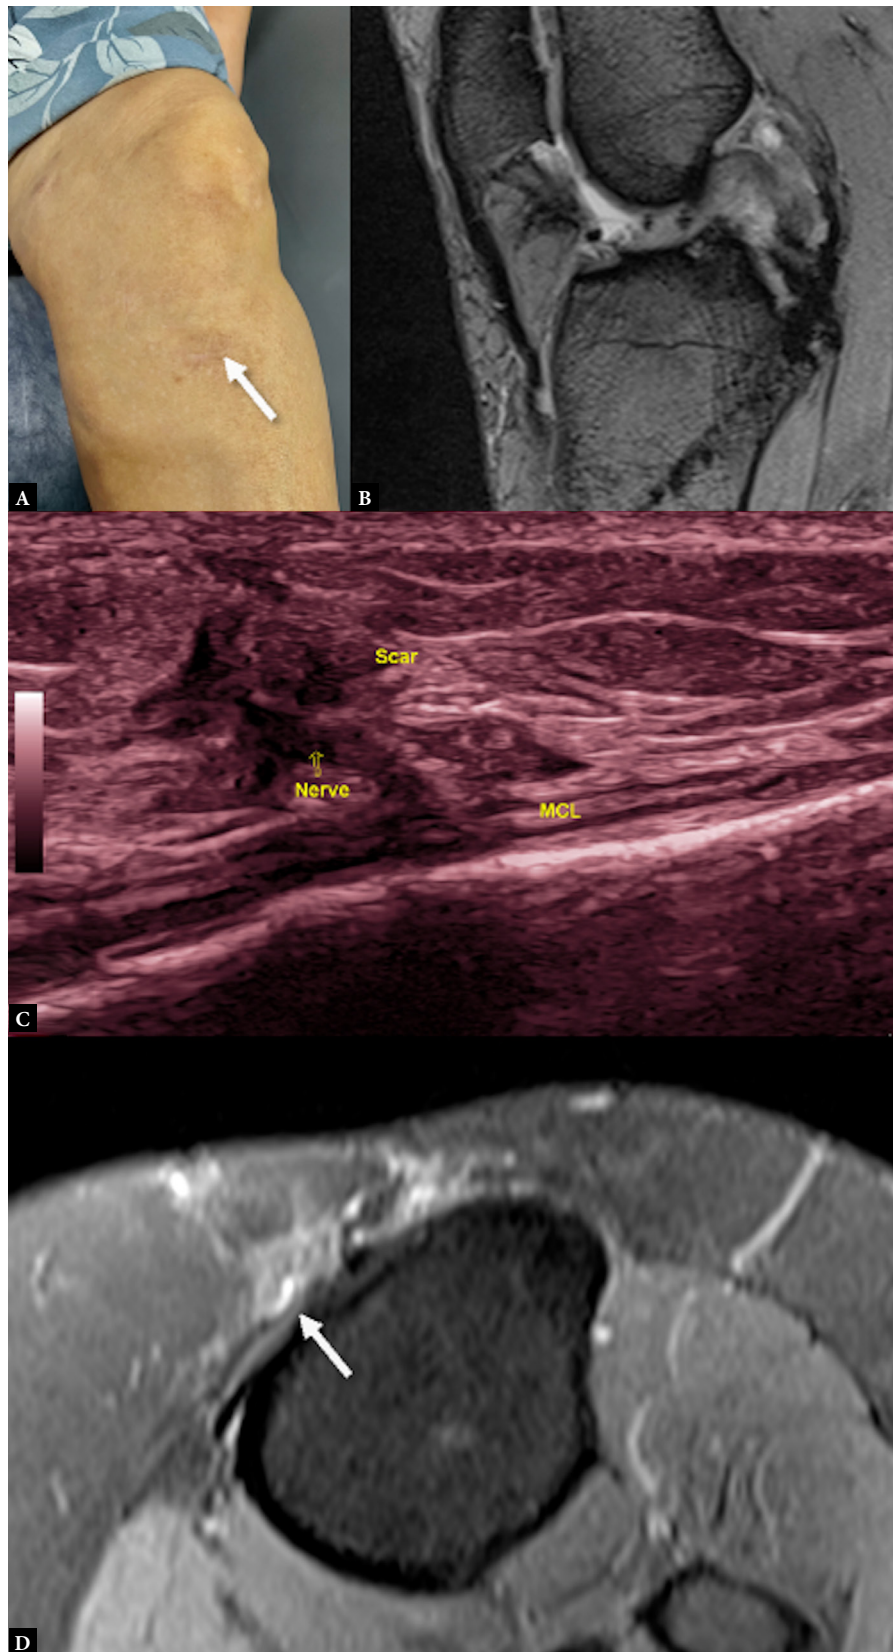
Inferomedial genicular nerve scar entrapment following posterior cruciate ligament (PCL) repair A. Clinical image showing the scar site B. Fat-suppressed proton density sagittal weighted MRI showing postoperative changes in PCL; no obvious abnormality was appreciated on MRI explaining the patient's symptoms C. Ultrasound image with the probe placed along the distal tibial insertion site of the medial collateral ligament (MCL) showing nerve entrapped within scar tissue, corresponding precisely to the site of maximum tenderness. D. Retrospective review of the axial MRI images reveals the entrapped nerve as a focal hyperintense structure (arrow)
